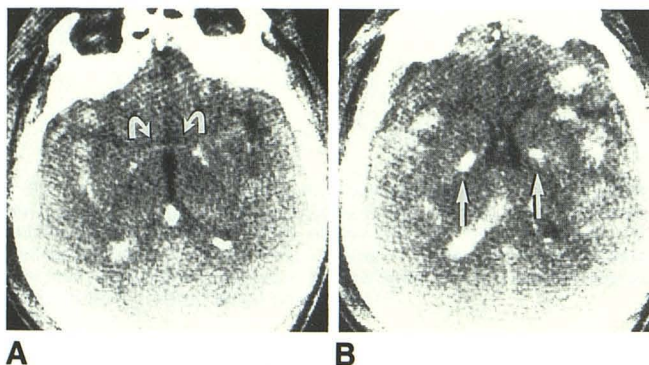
CT scans obtained at time of admission.
